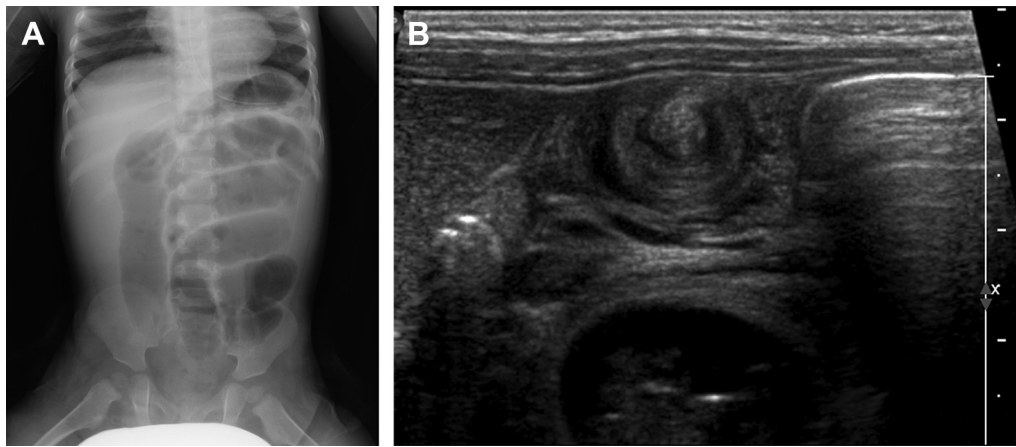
(A) Markedly dilated bowel loops are seen on an infantogram. (B) Whirlpool sign shown in right upper abdomen on an ultrasonographic scan.
